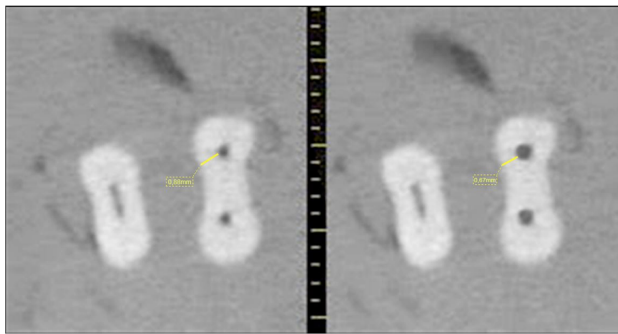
Representative axial section shows the measuring of thinnest dentin thickness in danger zone in initial and final CBCT scans.
